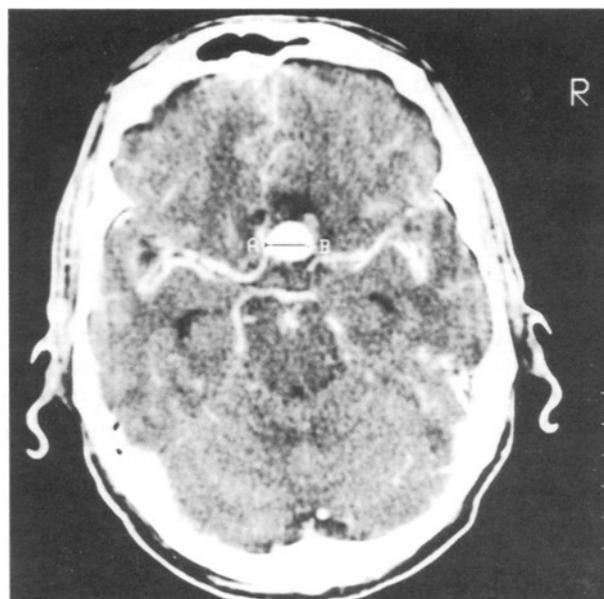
a. Preoperative infusion CT scan of a 56-year-old patient who presented with warning leak, showing a hyperdense filling at the ACoA complex, b. Left carotid angiogram revealing an aneurysm at the ACoA complex.
